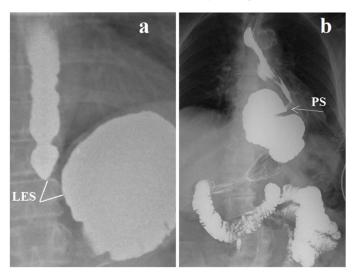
X-ray examination of EGJ. (a) Study with high pressure in the stomach (during lifting of straightened legs after ingestion of 200 ml of barium). The high pressure in the stomach caused a reflexive contraction of the LES. Its length is 1.4 cm (norm 3.4-4.0 cm). The width of the esophagus in the lower part is 1.8 cm, and in the middle part it is 2.4 (the normal maximal limit is 1.5 cm). The walls of the esophagus are uneven, indicating esophagitis. Reflux index - the ratio of the width of the esophagus to the length of the LES is 1.3. Normal RI <1. Conclusion: GERD, esophagitis. (b). X-ray of another patient 5 minutes after high pressure was created. S-shaped esophagus after a failed Nissen fundoplication. Sharp expansion of the esophagus below the proximal sphincter (PS). Conclusion: Severe GERD with gaping EGJ. The sigmoid esophagus.
